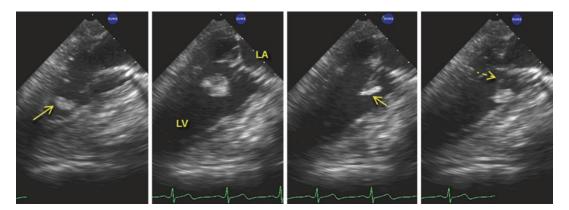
Serial transesophageal three-chamber views of the left ventricular outflow tract of a patient with a hypermobile papillary fibroelastoma. In diastole (left panel) the tumor is seen in the left ventricle (arrow) while in systole (third panel) the tumor is thrown into the left
